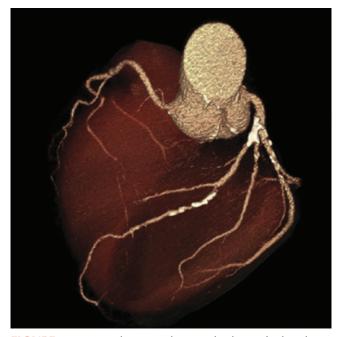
Volume-rendering display of the heart obtained during cardiac computed tomography angiography (CCTA). This image can be rotated for three-dimensional visualization. (Courtesy Lance Blackwell, TeraRecon, Inc.)
